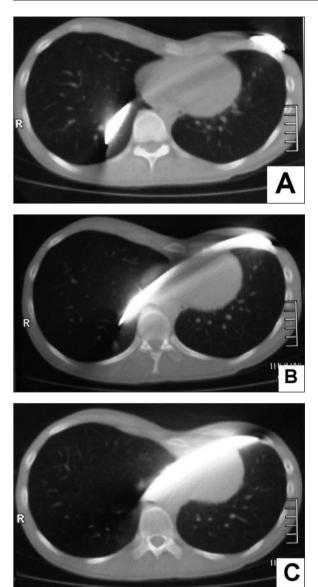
Computed tomography scans of the thorax with bar.
